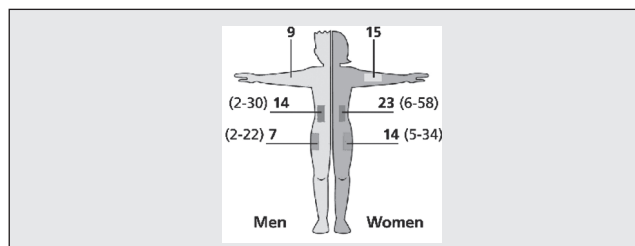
Subcutaneous thickness (in mm) for male and female adults. Means (in bold) and ranges (in parenthesis) reflect results from a number of ultrasound-based studies [47,109,122-126].
